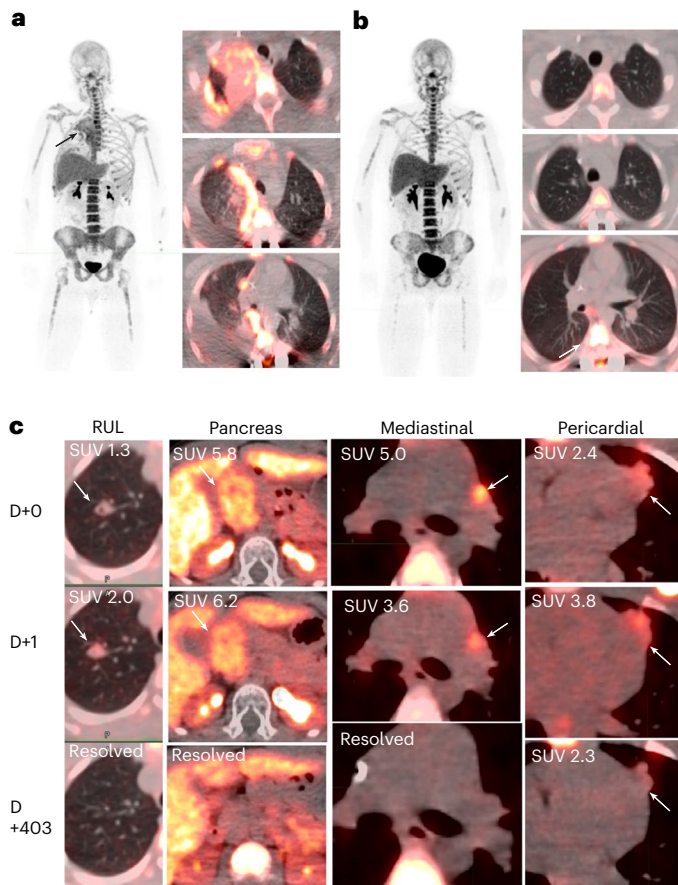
^{18}F -FLT is a biomarker of tumor response and recurrence. ^{18}F -FLT PET scan demonstrating high tumor burden at onset of therapy (a) with tumor response and one persistent lesion (white arrow) in patient 023 after four cycles of trabectedin/irinotecan (b). c, ^{18}F -FLT shows variable signal suppression in patient 006 with trabectedin exposure and near-complete resolution of tumor by day 403 with one persistent lesion that proved to be the site of recurrence. D, day; RUL, right upper lobe; SUV, standard uptake value.
